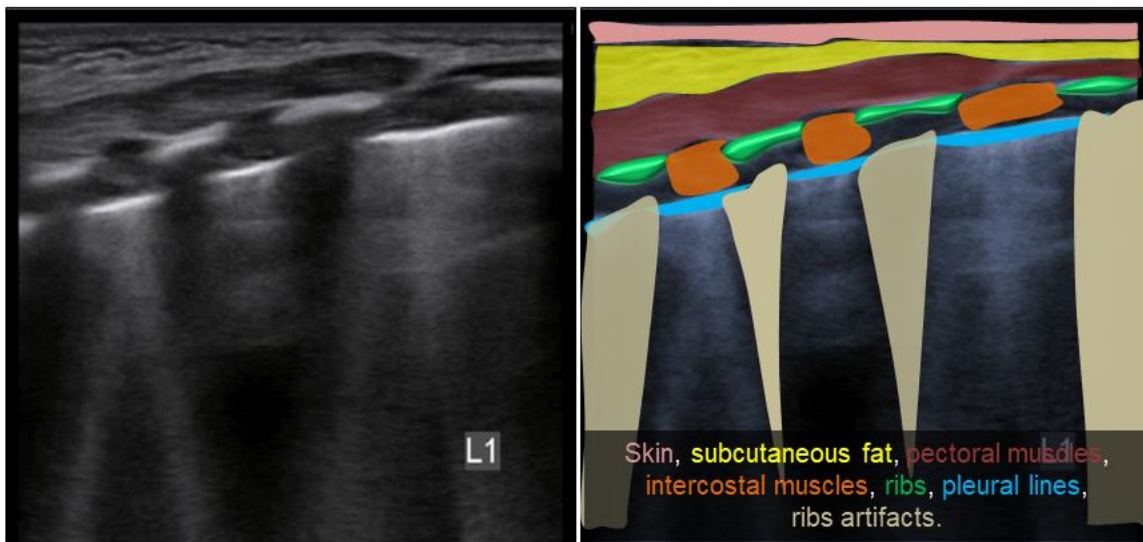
Lung ultrasonography image of left anterior area
